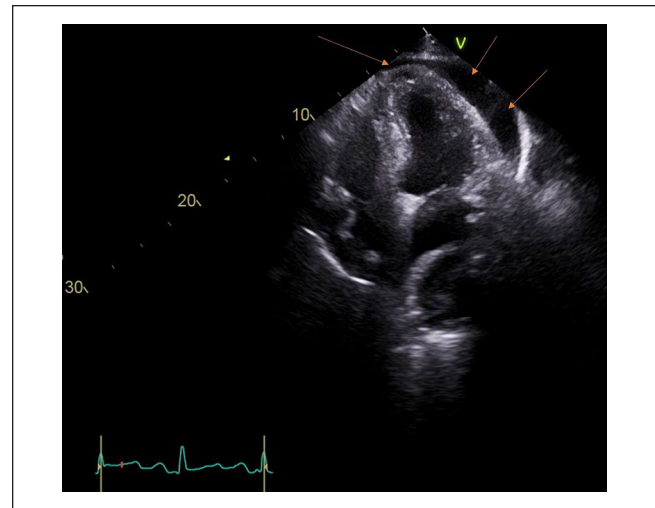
Transthoracic echocardiogram apical 4-chamber view also showing moderate to large circumferential effusion (orange arrows). Cultures of the pus that was subsequently drawn grew *Streptococcus anginosus* and *Actinomyces odontolyticus*.
